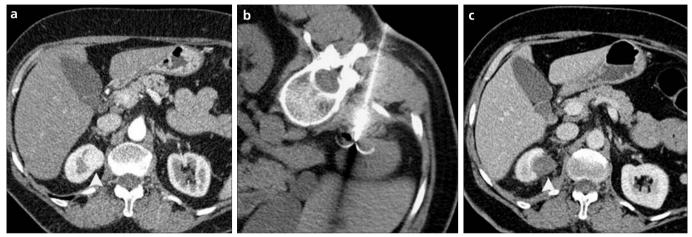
a–c. A 65-year-old woman with a 2×2 cm right kidney mass, which was found incidentally. The patient has a pacemaker due to heart block. Axial CT image (a) shows an enhancing mass (*arrowhead*) in the medial aspect of the upper pole of the right kidney. Percutaneous RF ablation (b) was performed using CT guidance and a 3 cm expandable, multi-tined RF ablation electrode (Boston Scientific Corporation). RF energy was applied starting from 40 watts and gradually increased to 150 watts over 13.5 min, including a booster dose. After the procedure, the patient developed mild hematuria, which subsided spontaneously. Follow-up CT (c), which was obtained the next day, showed good tumor coverage with no evidence of suspicious enhancement (*arrowhead*) in the tumor to suggest residue.
